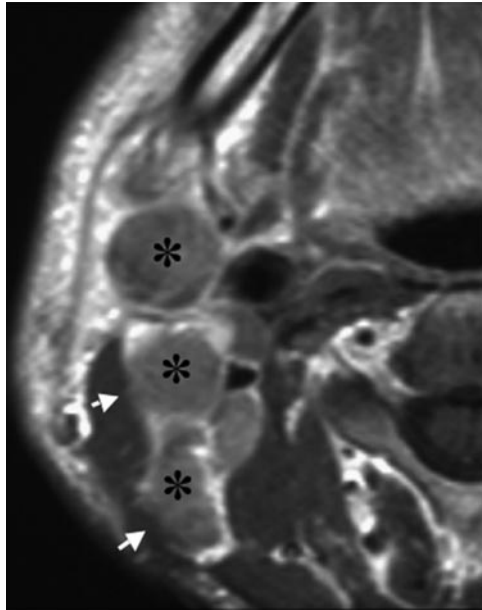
A 51-year-old man with upper gingival carcinoma. Gadolinium-enhanced axial T1-weighted (TR/TE = 500/15) image shows the irregular boundary (shaggy margin, arrows) of contrast-enhanced metastatic nodes with ENS (asterisk) at levels II and III.
